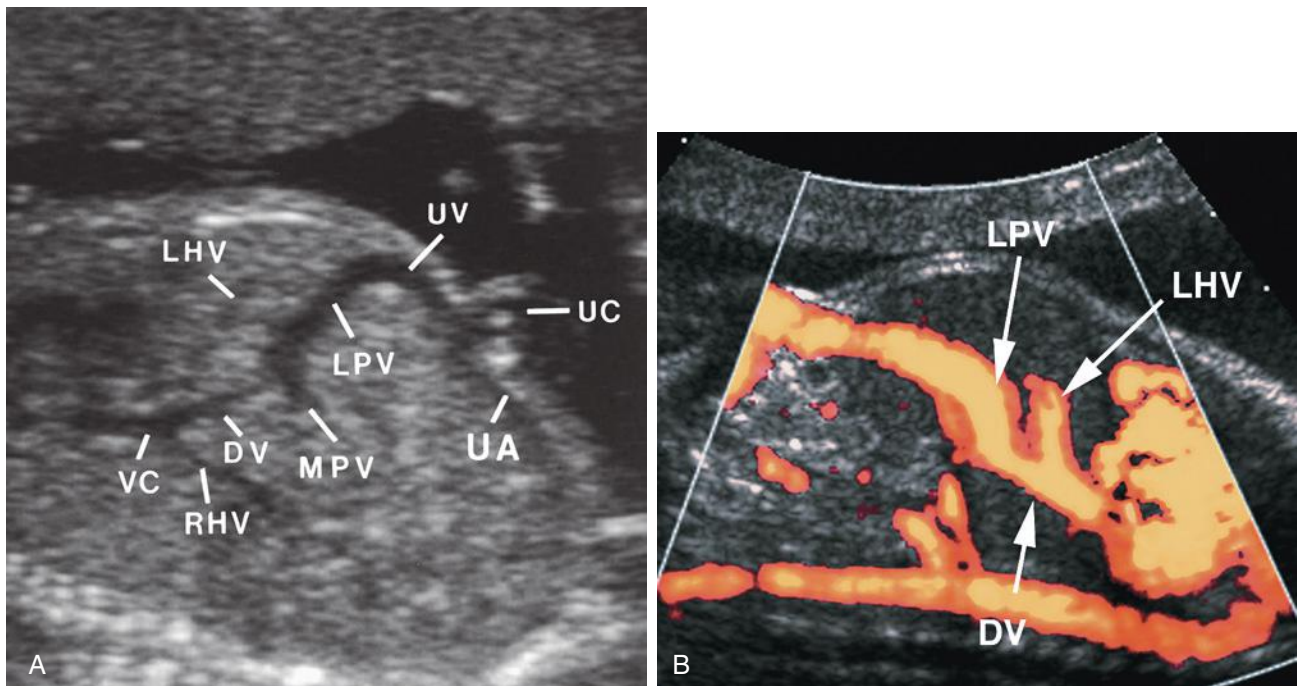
Midsagittal sonograms of the umbilical circulation in gray scale (A) and nondirectional color Doppler (B). DV, ductus venosus; LHV, left hepatic vein; LPV, umbilical segment of left portal vein; MPV, main portal vein; RHV, right hepatic vein; UA, umbilical artery; UC, umbilical cord; UV, umbilical vein; VC, inferior vena cava.
